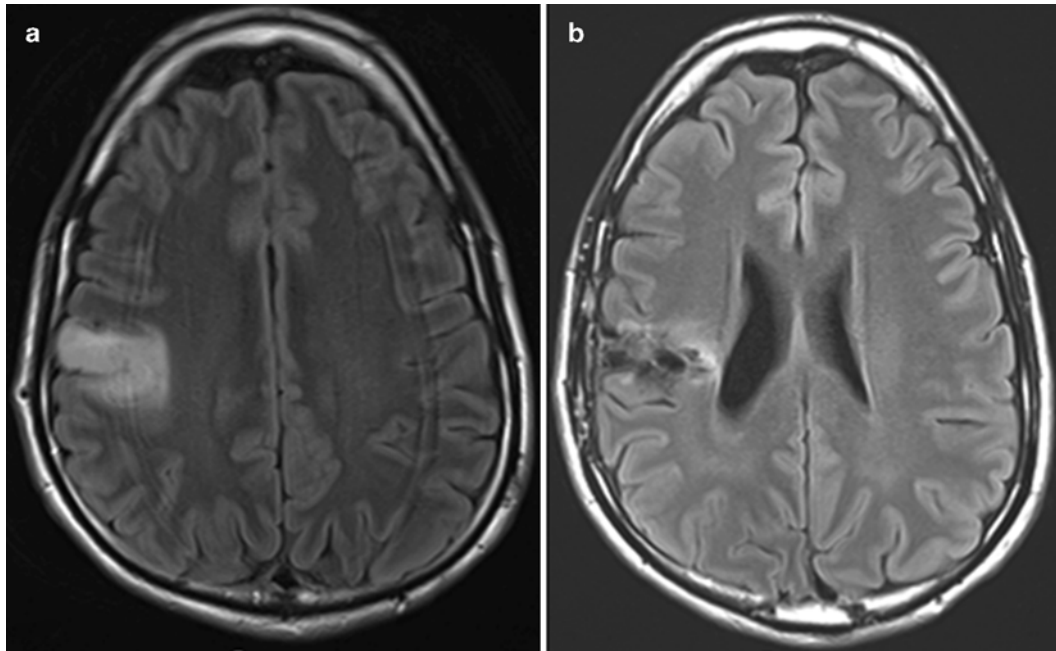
Low-grade oligodendroglioma of the right frontal lobe as depicted in FLAIR brain MRI sequences before (a) and after (b) surgical resection. This is a classic presentation with the predominant involvement being in the cortical rather than deep regions.
